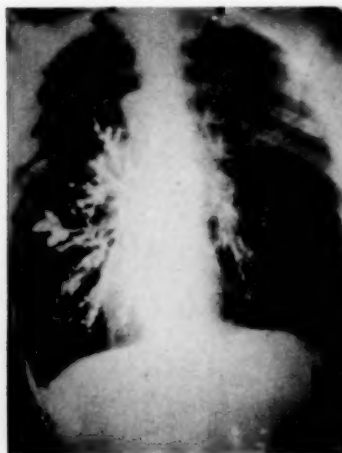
Roentgenogram of patient showing multiple large bronchiectatic cavities.
